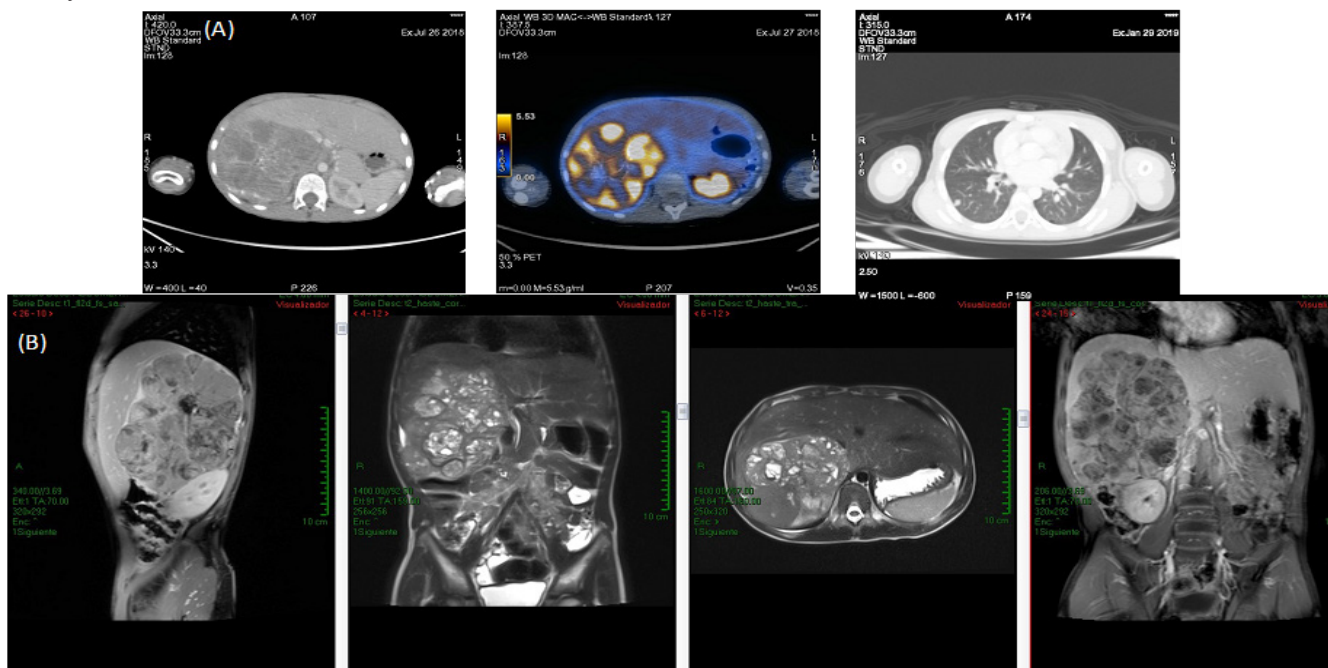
(A) Diagnostic CT scan (2018): heterogeneous liver lesion with lobulated edges, which displaces intra-abdominal structures, not being able to distinguish structures such as kidney or adrenal gland. (B) MRI: hyperintense lesion at the liver level, which is observed displaced (12.5 x 9.2 x 8.5).
